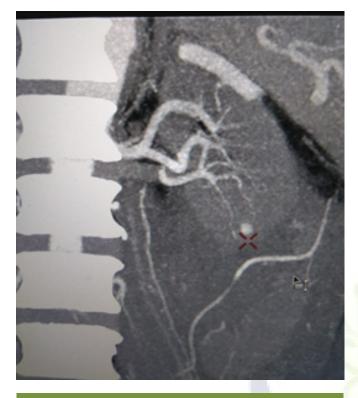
Coronal reformatted CT angiogram arterial phase demonstrating pseudoaneurysm from the inferior segmental polar branch of left renal artery
